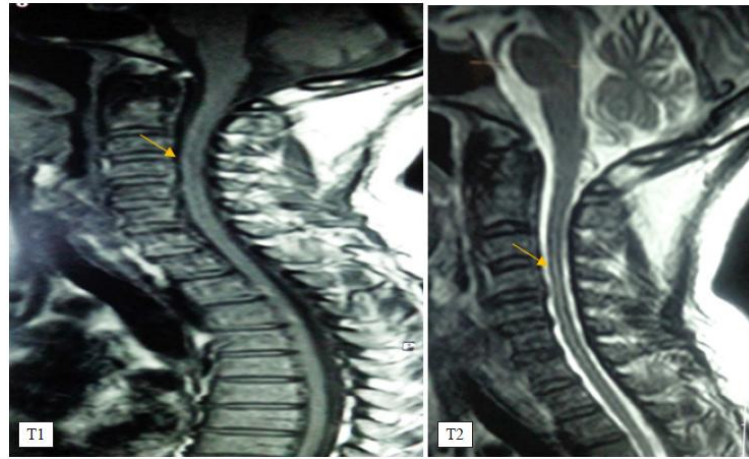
Magnetic resonance imaging of the spinal cord, sagittal section in T1 and T2 sequences showing the signals characteristic of cervicodorsal filiform ischemia
